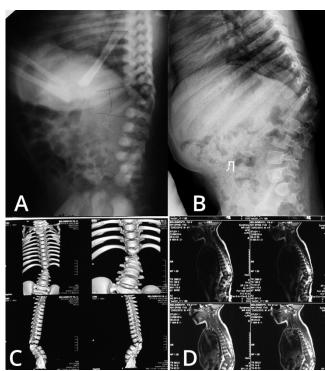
Radiography, CT and MRI of the patient, 4 years 8 months old (case 3): A – lateral radiograph at the age of 1 month: kyphotic deformity, hypoplasia of vertebral bodies of the thoracolumbar junction; B – lateral radiograph at the age of 4 years 8 months: deformity progression, dislocation of the spine at the SSD level; C – 3D-reconstruction of the spine at the age of 4 years 8 months: hypoplasia of the vertebrae at the level of the thoracolumbar junction with absence of posterior vertebral structures and kyphotic deformity; D – sagittal slices of T2-weighted MRI at the age of 4 years 8 months show that the spinal cord ends at the level of the lower thoracic spine, and caudally to SSD the contours of the spinal cord and the dural sac with the cerebrospinal fluid are visualized. At kyphosis apex, there is total stenosis
